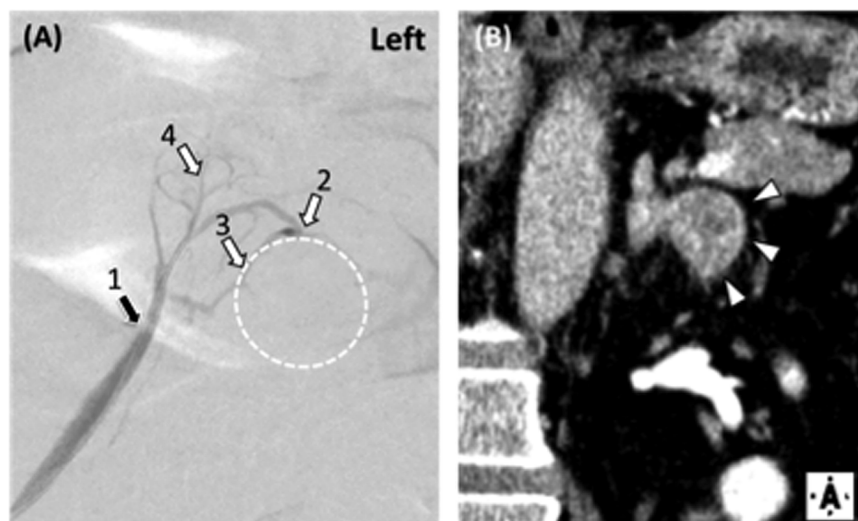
Adrenal venography performed to carry out segmental adrenal venous sampling (S-AVS) (A) and coronal CT image (B) of the left adrenal gland in a 56-year-old man who was finally diagnosed recurrent APA. The adrenal tumor was detected by CT (B, arrowheads) and projected into the venography (A, dotted circle). The sampling point from a central vein is indicated by black arrow number 1 (A). Sampling points from tributary veins are indicated by white arrows 2, 3, and 4 in (A). Abbreviations: APA, aldosterone-producing adenoma; CT, computed tomography.
